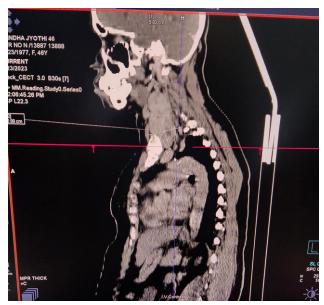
CT scan showing retrosternal thyroid
